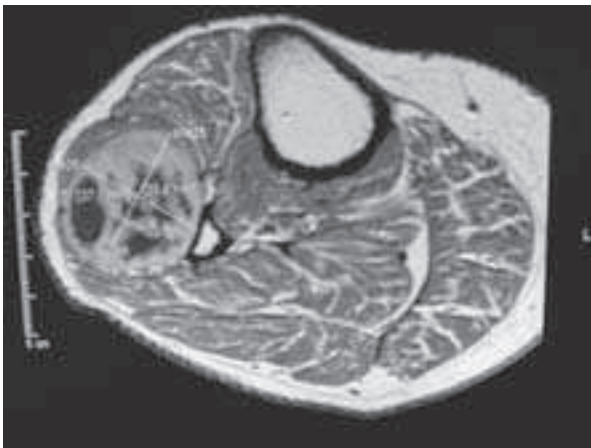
Horizontal MRI of neurinoma
